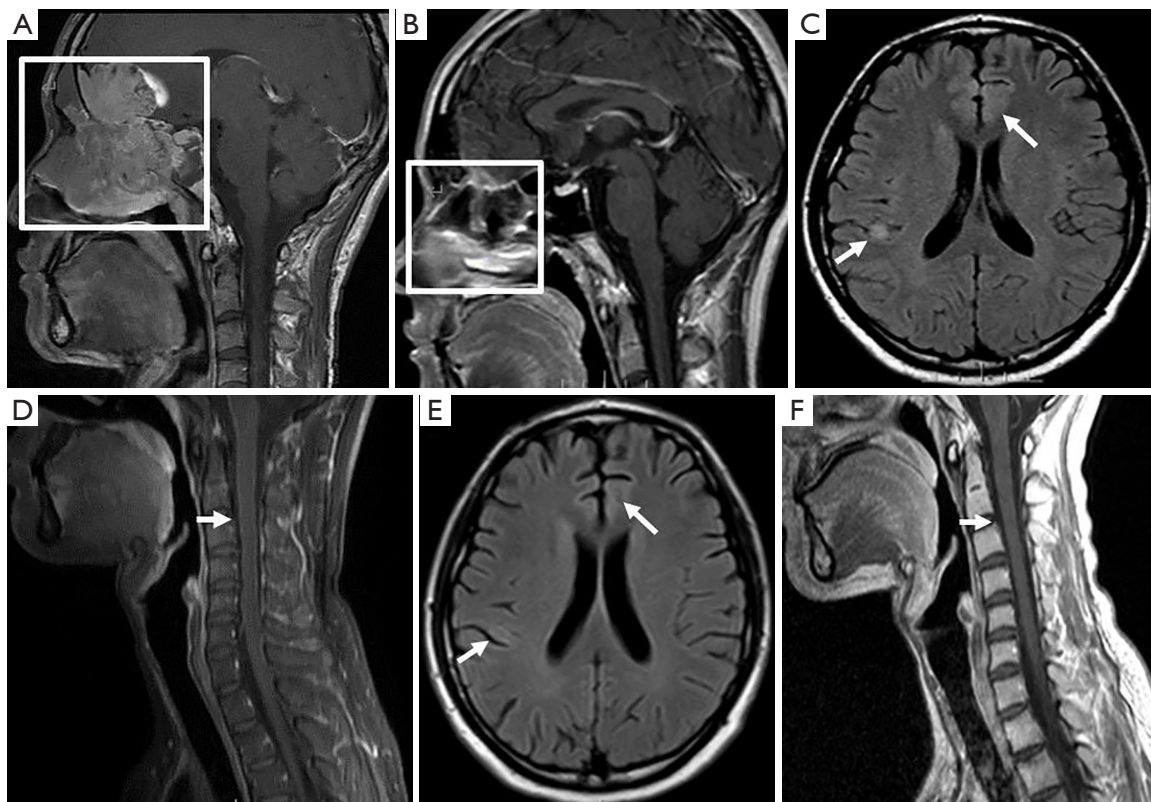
Changes in magnetic resonance imaging findings of olfactory neuroblastoma. A contrast-enhanced sagittal magnetic resonance T1-weighted sequence of the brain (A) showing an expansile lesion involving the ethmoid sinus, sphenoid sinus, nasal cavity, and frontal lobe with bone destruction. After 6 courses of chemotherapy and immunotherapy, a contrast-enhanced sagittal T1-weighted sequence (B) indicated that the above lesion had obviously diminished. At the same examination, an axial T2-weighted FLAIR sequence (C) revealed some new expansile lesions presenting as a hyperintensity nodule in the right parietal sulcus and a patch in the left frontal lobe. Linear, meningeal-enhanced thickening was observed on T1-weighted, fat-suppression, gadolinium-enhanced spinal magnetic resonance imaging representing leptomeningeal disease (D). The lesion was suspected to be immune encephalitis. After adsorption treatment, the new lesions had almost disappeared in the follow-up axial T2-weighted FLAIR (E) and sagittal T1-weighted contrast-enhanced images (F). Boxes show tumor location, and arrows show intracranial and spinal cord lesions. FLAIR, fluid attenuated inversion recovery.
